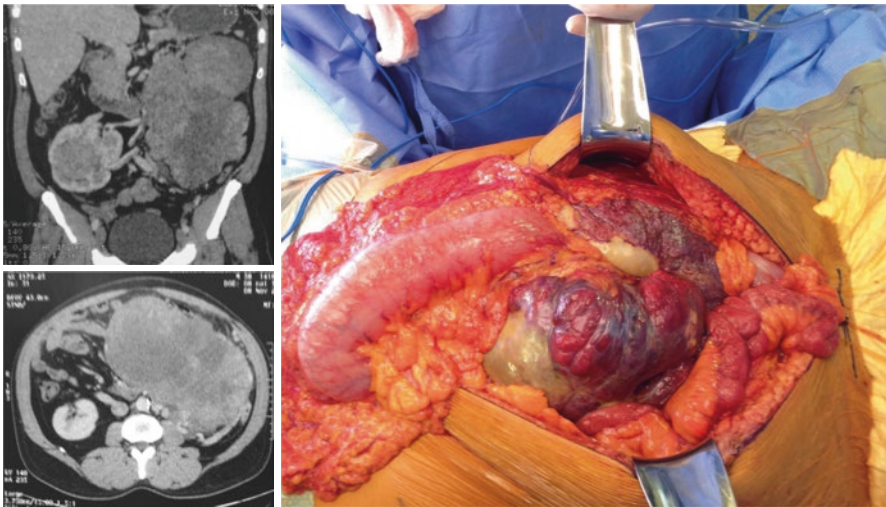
A 60-year-old male patient, complaining of pain associated with increased abdominal volume. On physical examination, a large abdominal mobile mass was noted. A heterogeneous lesion is observed on CT scan, with areas of necrosis and a “geographical” contour. Renal anatomical variation. Operative finding of a massive primary lesion of the proximal jejunum. Segmental enterectomy was performed with complete resection. Definitive diagnosis of GIST
